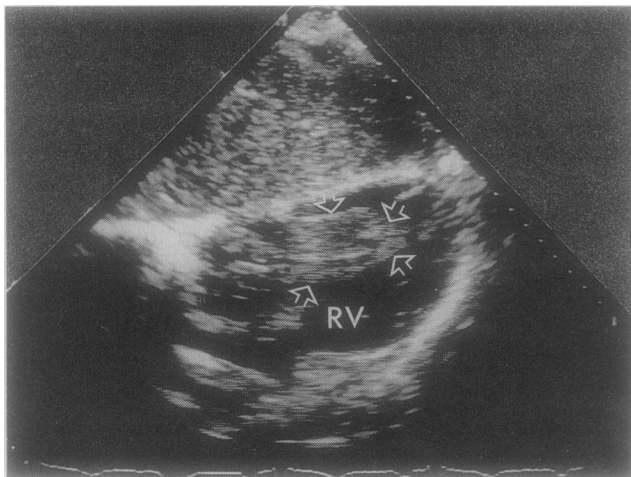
Two-dimensional echocardiogram, showing subcostal view of mass in right ventricle.
